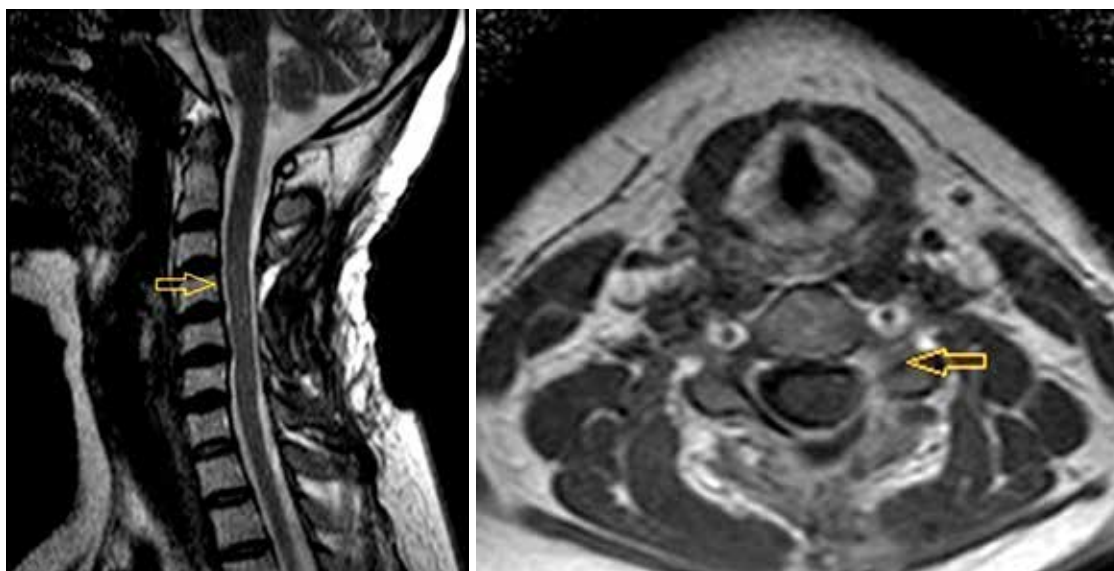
MRI of the cervical spine with contrast, T2 mode. Postoperative follow-up six months after meningioma removal. Simpson II
